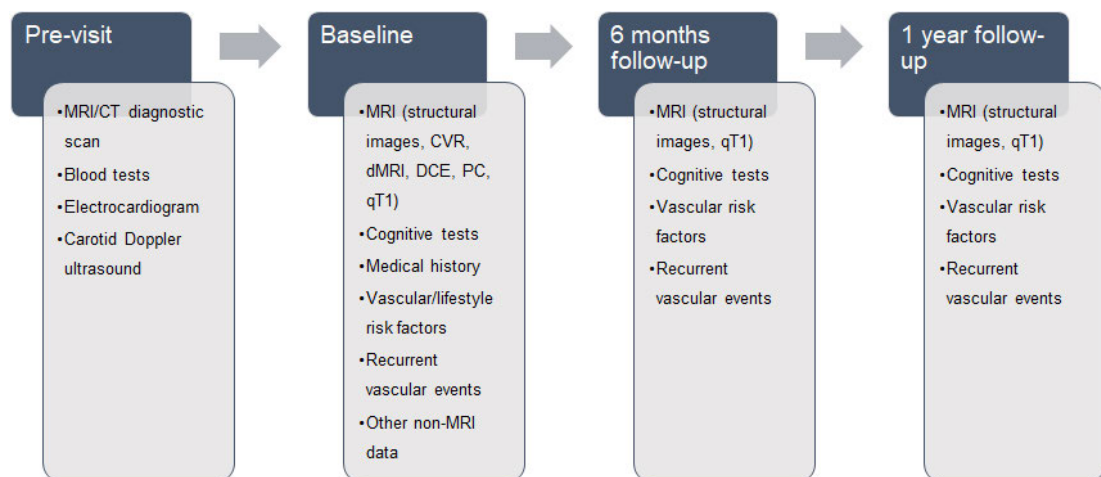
Study protocol from pre-visit assessment to one year follow-up. Stroke diagnosis was performed at pre-visit assessment. Thereafter, patients had a minimum of three visits where MRI and non-MRI data were collected.
